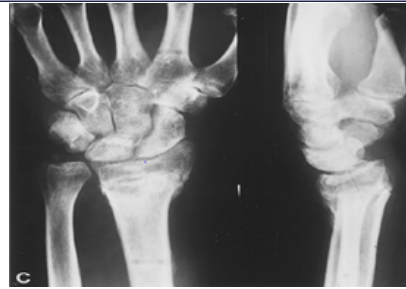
AP and lateral X-ray after removal of fixator at 12 weeks follow-up.
